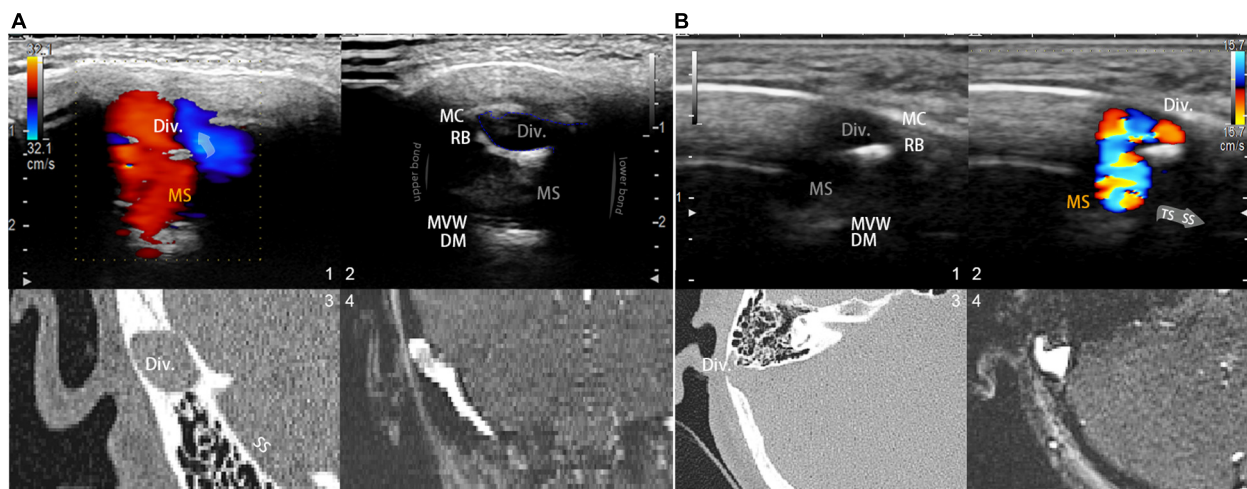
Visualization and insights of the RCCD ultrasound method. (A) (1) Coronal RCCD continuous wave mode view of the mainstream sinus and diverticular flows. The transparent arrow indicates mainstream sinus flow diversion into the diverticulum. Div. indicates diverticulum; MS indicates mainstream sinus flow. (2) A 2D-planar cross-sectional view of the diverticulum and the mainstream sinus anatomical structures. MC indicates mastoid cortex; RB indicates the remnant mastoid bone; MVW indicates the medial vascular wall; and DM indicates the layers of the dura mater. (3) Coronal CT view of the diverticulum and sigmoid sinus corresponding to the representative 2D ultrasonographic view. (4) Coronal 2D time-of-flight magnetic resonance imaging of the diverticulum and sigmoid sinus corresponding to the representative 2D ultrasonographic view. (B) (1) A 2D-planar axial view of the diverticulum and mainstream sinus anatomical structures. MC indicates the mastoid cortex; RB indicates the remnant mastoid bone; MVW indicates the medial vascular wall; and DM indicates the layers of the dura mater. (2) Axial RCCD continuous wave mode view of the mainstream sinus and diverticular flows. The gray arrow indicates the flow direction from the transverse sinus to the sigmoid sinus. Div. indicates diverticulum; MS indicates mainstream sinus flow. (3) An axial CT view of the diverticulum and sigmoid sinus corresponding to the representative 2D ultrasonographic view. (4) Axial 2D time-of-flight magnetic resonance imaging of the diverticulum and sigmoid sinus corresponding to the representative 2D ultrasonographic view.
